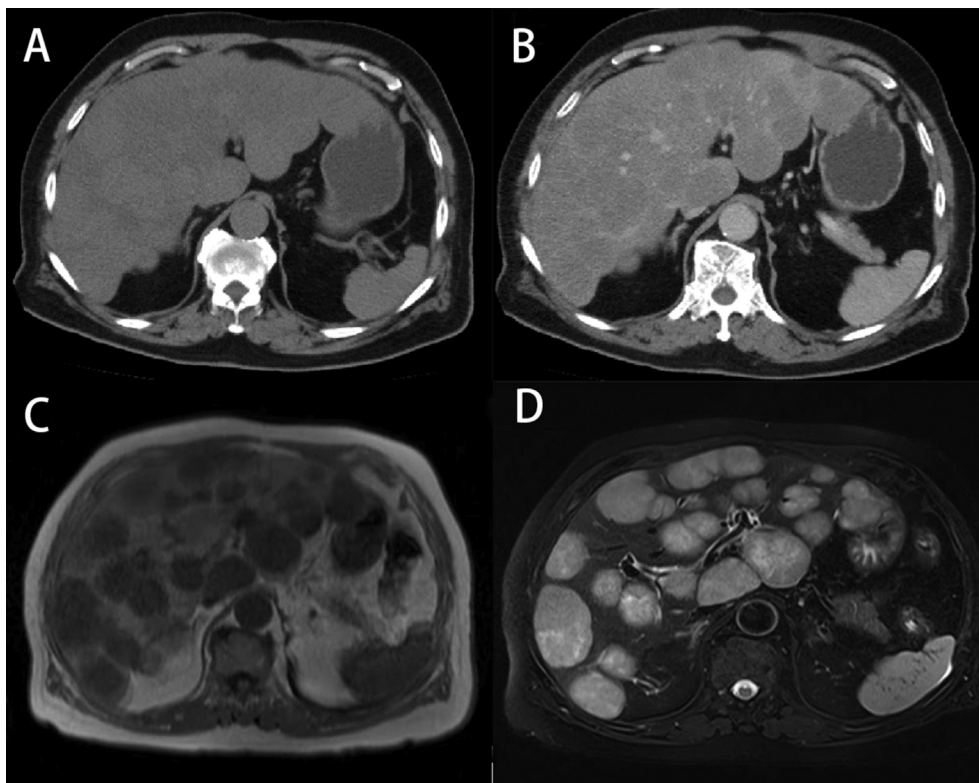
(A) Pre-contrast CT of abdomen revealed numerous nodular hepatic lesions. (B) Post-contrast CT of abdomen revealed the hepatic nodular lesions with poor enhancement in the arterial phase. (C) Low signal hepatic lesions were noted on the liver MRI T1-weighted image. (D) High signal hepatic lesions were noted on the liver MRI T2-weighted image.
